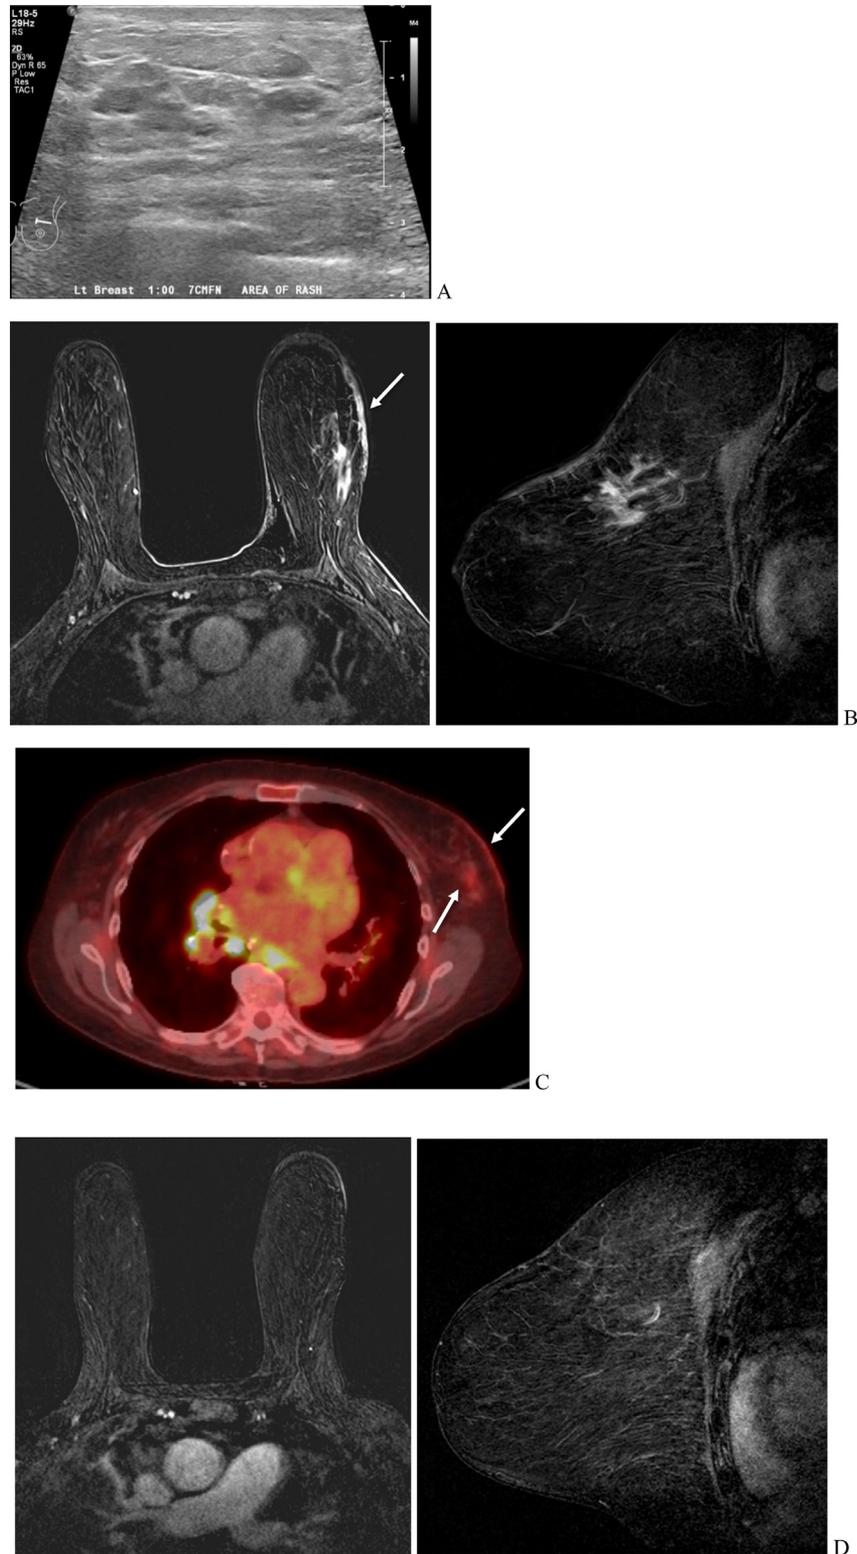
(A) – (A) Grayscale ultrasound image showing nonspecific hypoechoic tissue subjacent to the skin erythema, but no discrete mass. (B) Axial (left image) and sagittal (right image) subtraction images from contrast-enhanced MRI showing mass/nonmass enhancement in the upper-outer left breast, with associated skin enhancement and thickening (arrow). (C) ^{18}F -FDG PET/CT showing mild FDG uptake associated with the left breast mass and skin (arrows). FDG-avid mediastinal adenopathy attributable to sarcoidosis, with long-term imaging stability. (D) Axial (left image) and sagittal (right image) subtraction images from post-neoadjuvant treatment MRI showing resolution of prior abnormal enhancement in the left breast.
